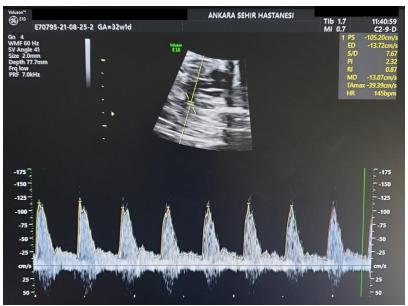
Doppler waveform of aortic isthmus
